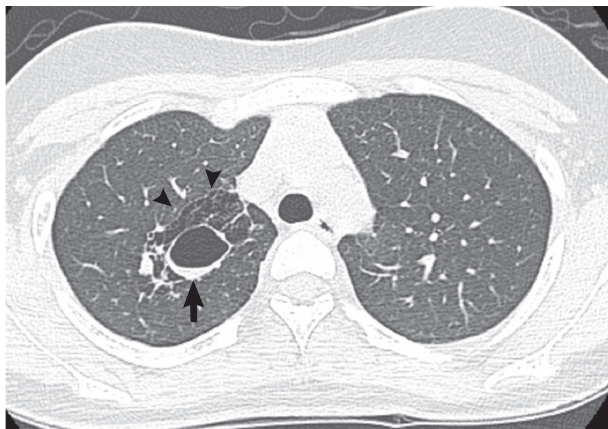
Axial computed tomography image shows a cystic lesion measuring 2.5 cm with an air fluid level (arrow) in the right upper lobe and it is surrounded by small multicystic lesions (arrowheads).
